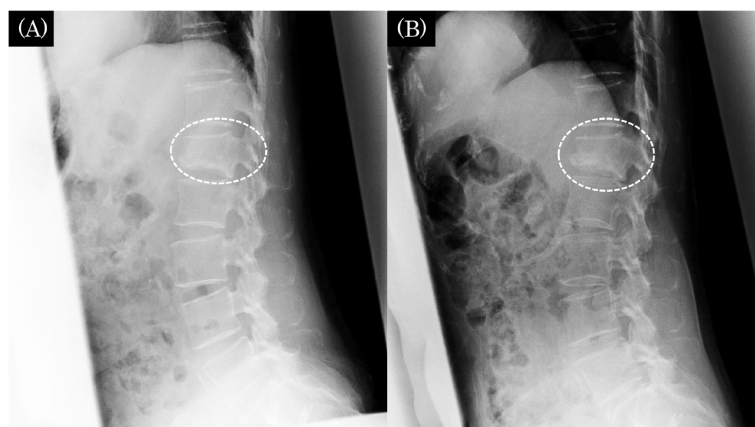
Radiography of lumbar spine.
